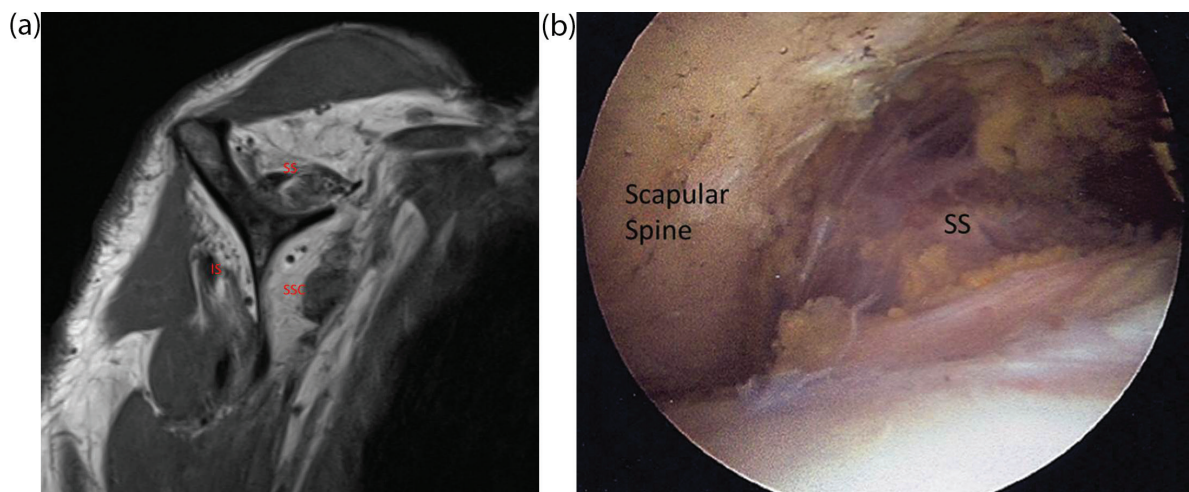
Fatty atrophy of the superior rotator cuff. (A) Sagittal MRI view of a right shoulder showing severe fatty degeneration (more than 50% of muscle volume replaced by fat) of the supraspinatus (SS), infraspinatus (IS), and subscapularis (SSC) muscles. (B) Arthroscopic view of the supraspinatus (SS), demonstrating severe muscle atrophy (view from a posterolateral subacromial portal in the right shoulder).
